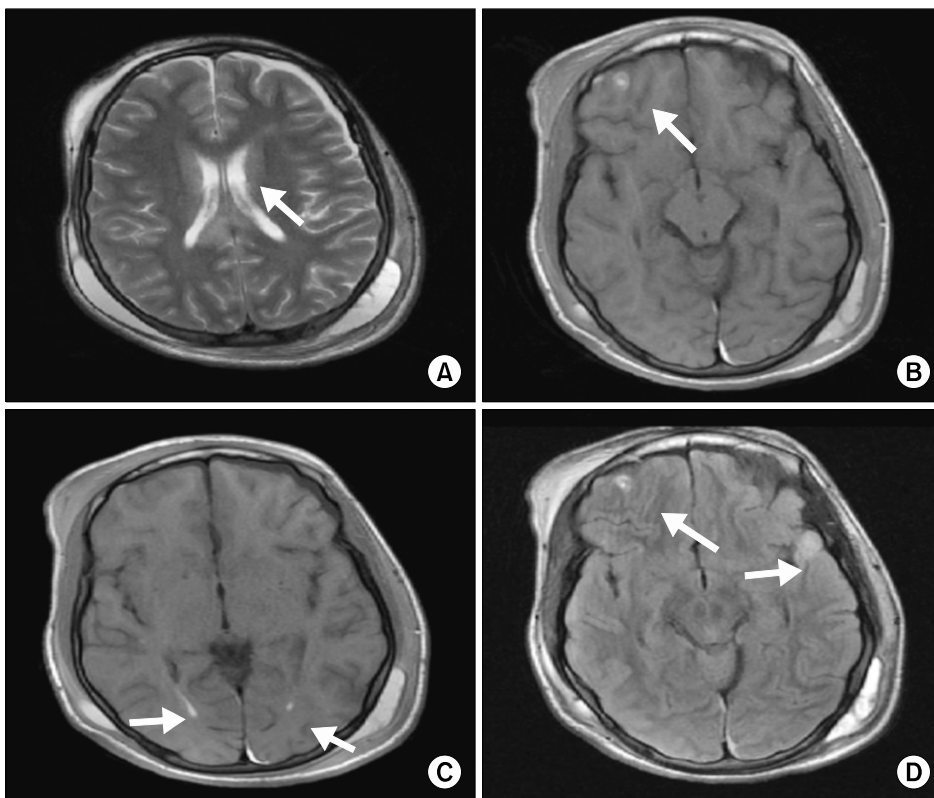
(A) On the T2-weighted axial image, increased focal signal intensity in corpus callosum. (B) On the T1-weighted axial image, hemorrhage and contusion in right frontal lobe grey matter. (C) On the T1-weighted axial image, minimal intraventricular hemorrhage. (D) On the fluid-attenuated inversion recovery (FLAIR) examination axial image, contusion and related increase in focal signaling in the right frontal and left temporal lobes grey matter.
